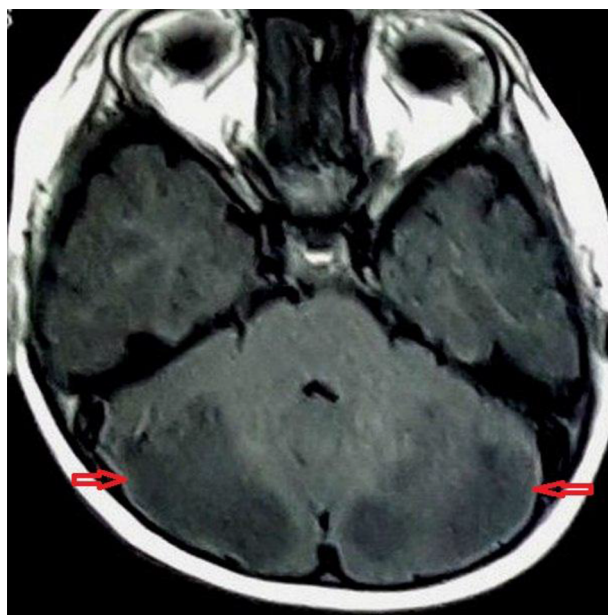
Axial T1 Magnetic Resonance Imaging Indicating Bilateral Symmetric Hypointensity in Cerebellar Hemispheres With Mild Narrowing of 4th Ventricle
